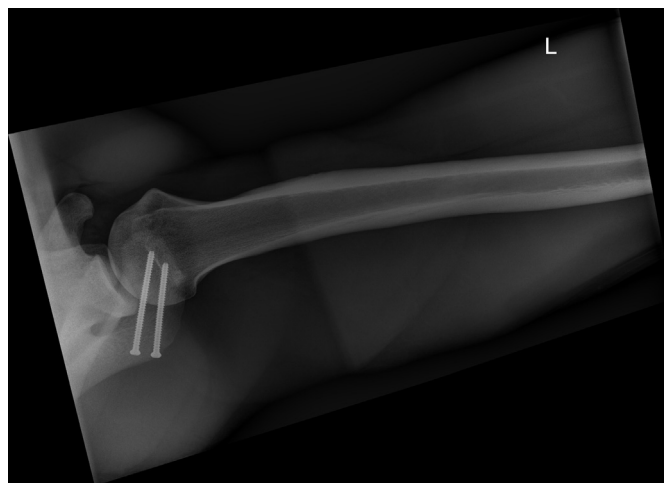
Axillary view radiograph of a left shoulder showing successful surgical fusion of mesoacromiale using 2 retrograde screws (3.5-mm). The acromion maintains its preoperative length and the acromioclavicular joint remains intact.
